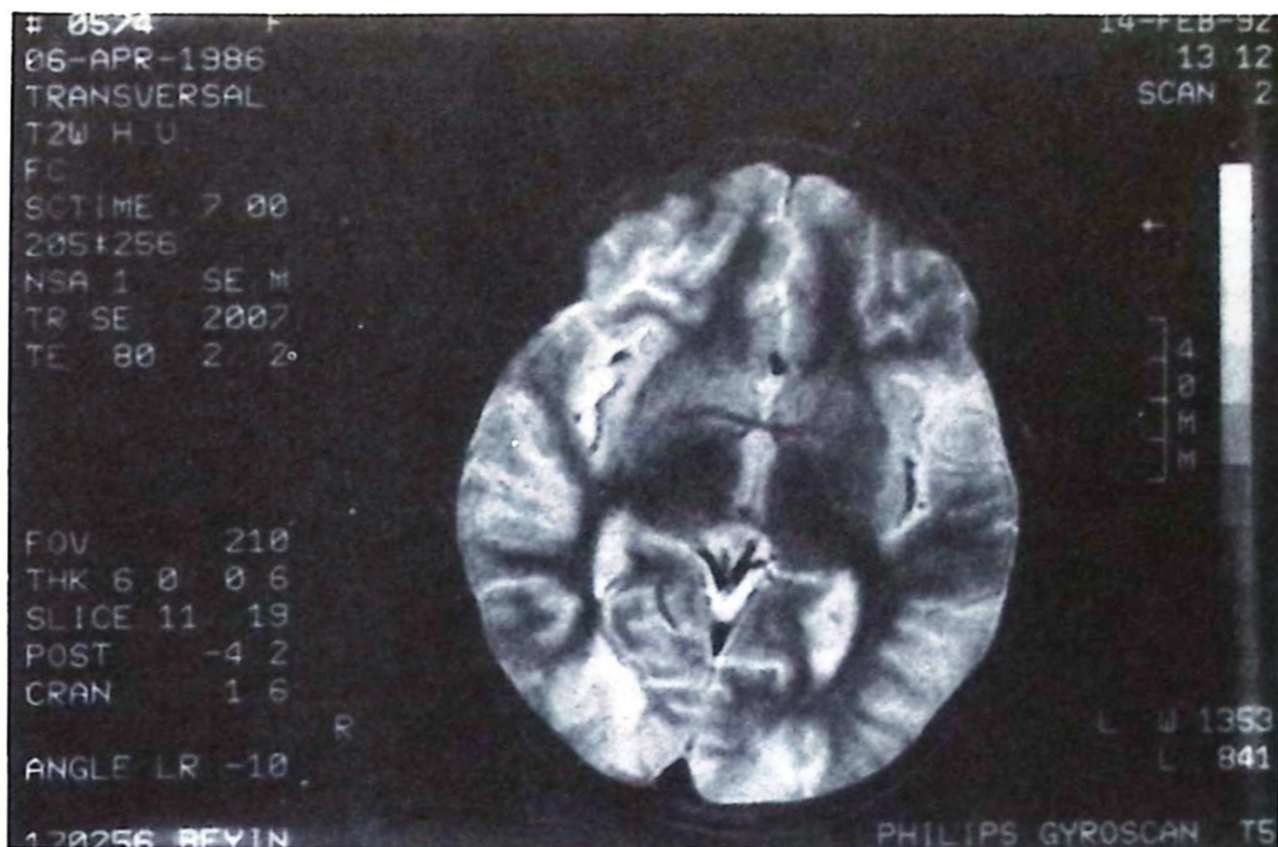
MRI performed one week later shows bilateral white matter hyperintensities in the occipital lobes extending into the U-fibers.
